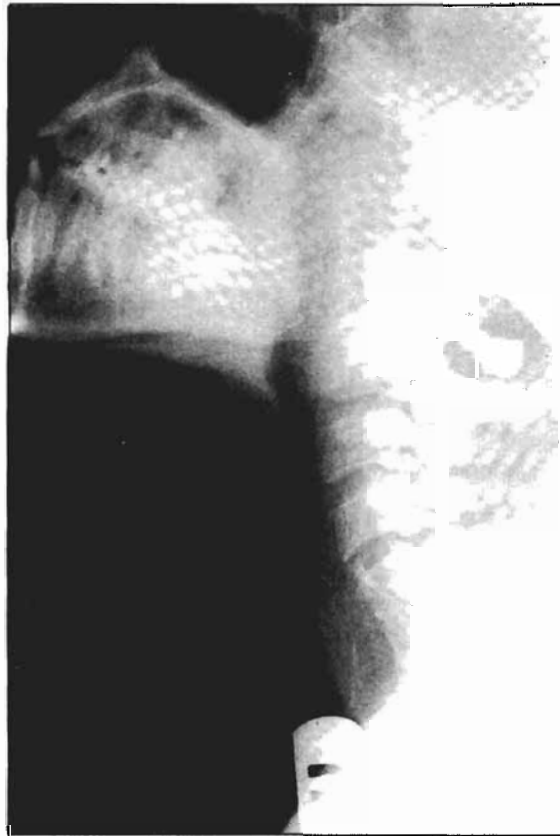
An X-ray of soft tissue neck (lateral view) showing hypertrophy of adenoid causing narrowing of the air column.
